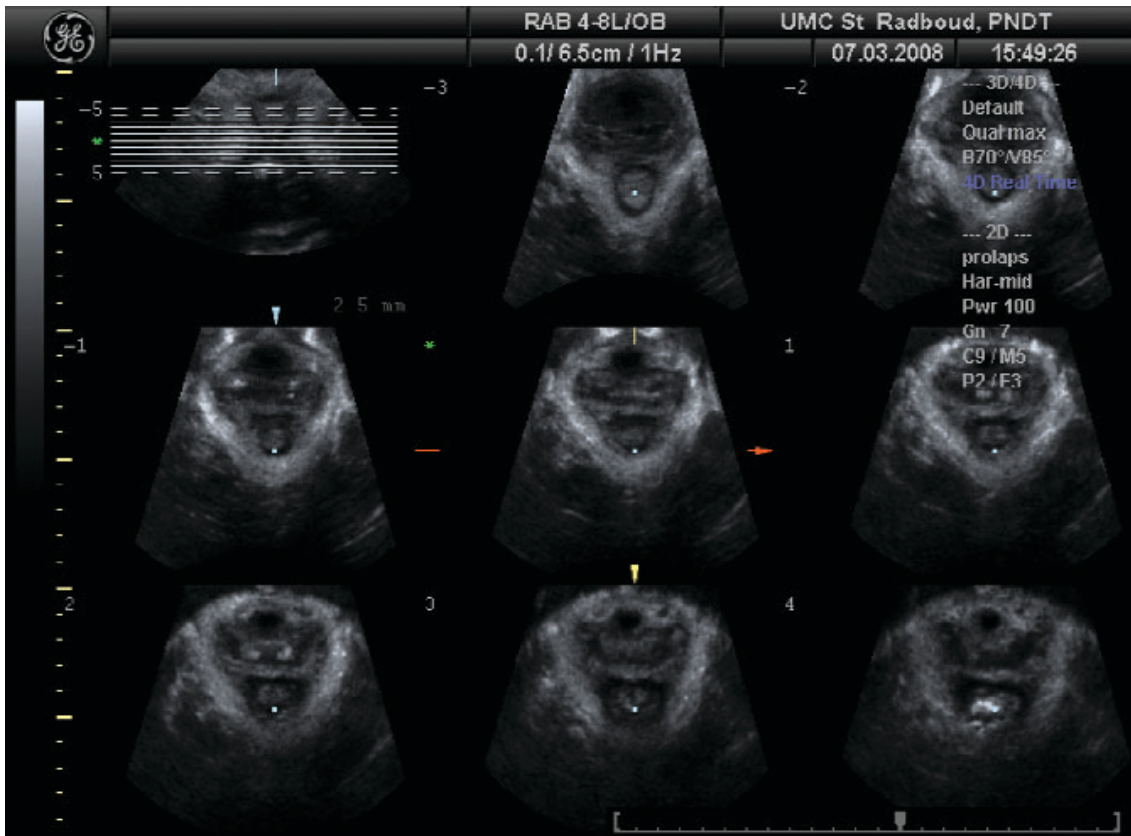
Tomographic ultrasound imaging (TUI) in oblique axial plane. Normal attachment of the levator ani muscle.
